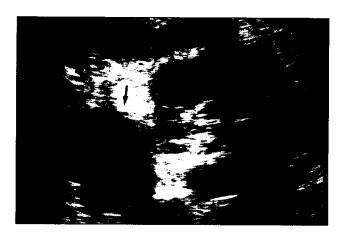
Ultrasound (longitudinal section) showing the left adrenal mass (arrows), measuring 9.5 x 4 cm (arrowhead = kidney)
